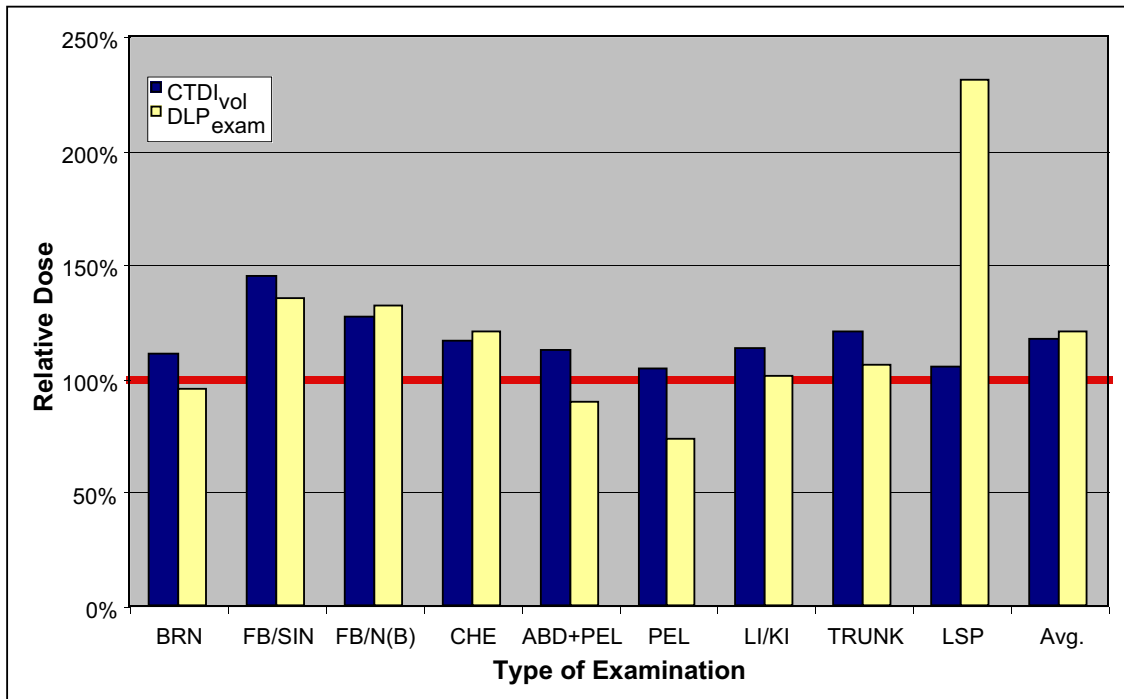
Comparison of the results of the NEXT 2000 CT survey with those of the '99 German CT survey. Relative dose values are given for each type of examination in terms of volume CTDI per scan/rotation ($CTDI_{vol}$) and dose-length product per examination (DLP_{exam}). The red line at 100% represents the average of the '99 German CT survey for the pertaining type of examination and dose descriptor (for abbreviations see tab. 1, (B)=body mode).
